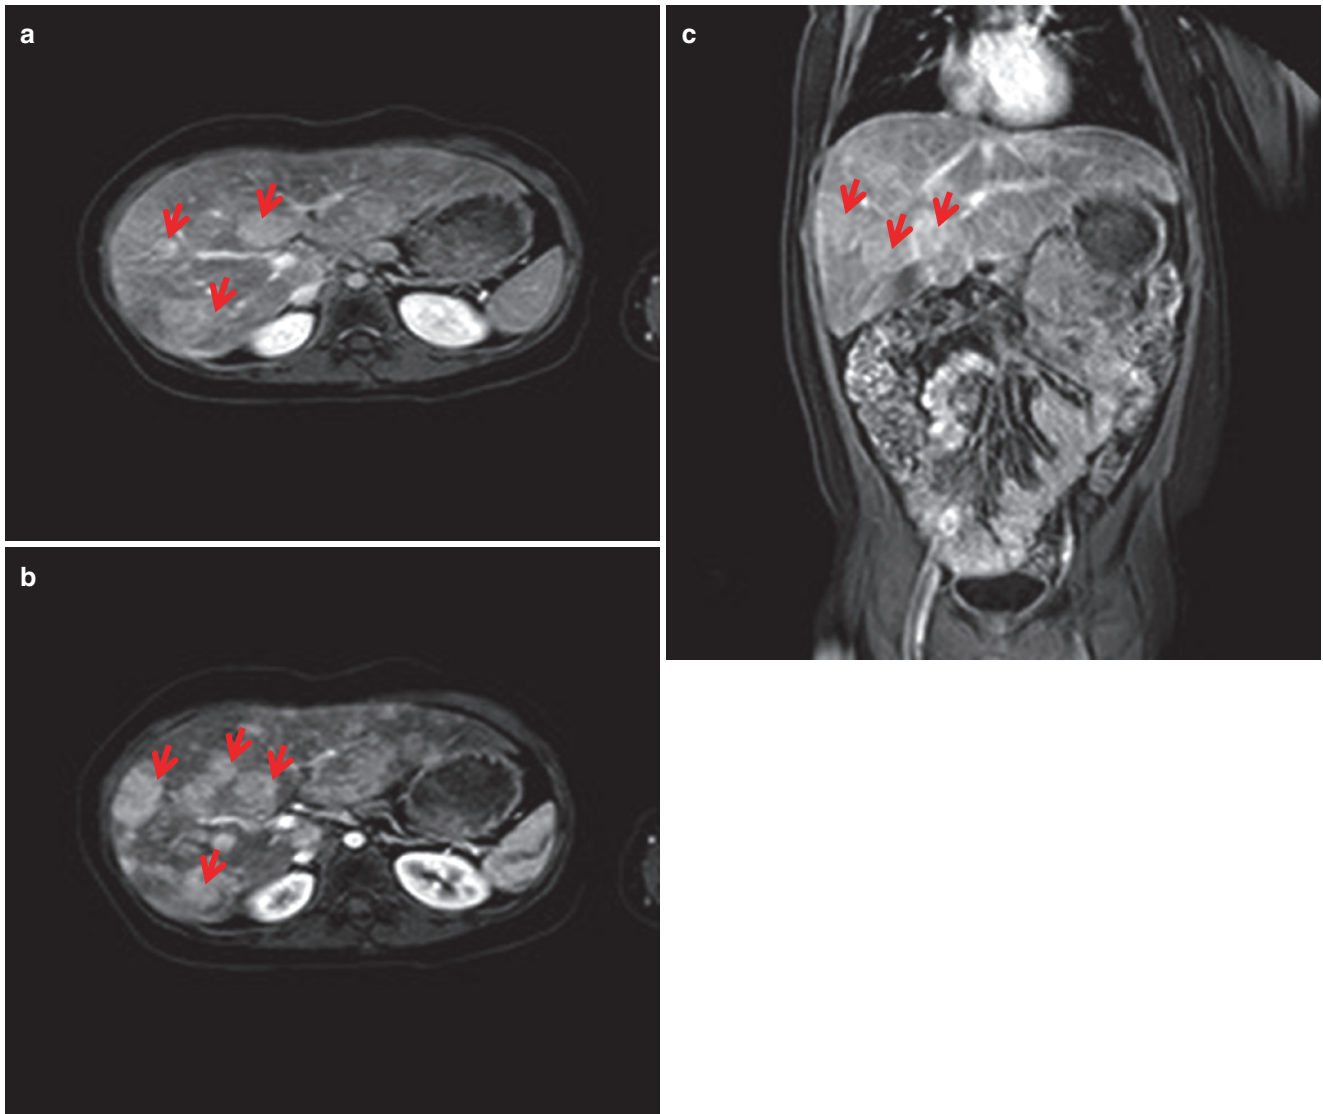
(a–c) MRI scan multi-focal-T1 post gad fat sat VIBE axial and coronal sequences reveal progressive peripheral to central enhancement of multiple hepatic lesions (arrows marking multiple nodules) suggestive of multiple FNH
